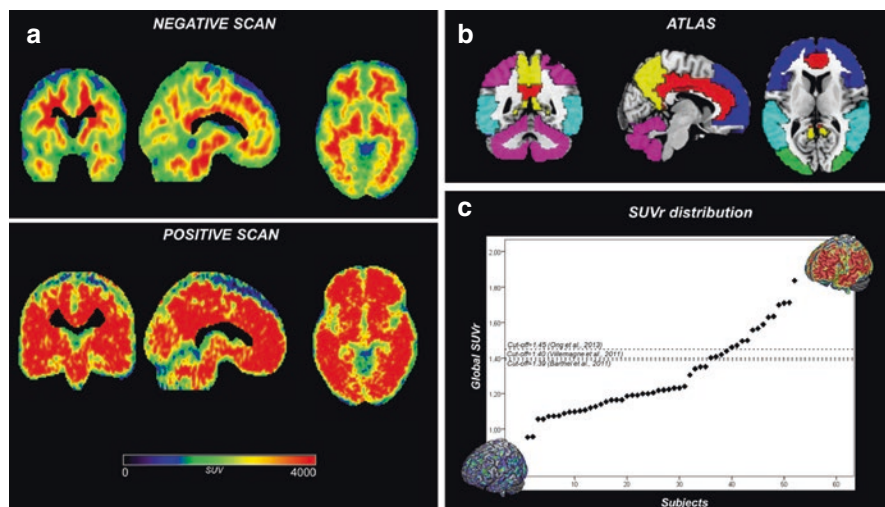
Amyloid-PET quantification steps. (a) Example of [^{18}F]florbetaben-negative and [^{18}F]florbetaben-positive scans. (b) Regions of interest overlaid on a standardized template used to calculate and estimate regional standardized uptake value ratios (SUVrs), according to Presotto and colleagues (Presotto et al. 2018). Distribution of SUVr in a heterogeneous sample of subjects and patients ordered from lowest to highest amyloid-PET uptake, underlying the concept of amyloid continuum
